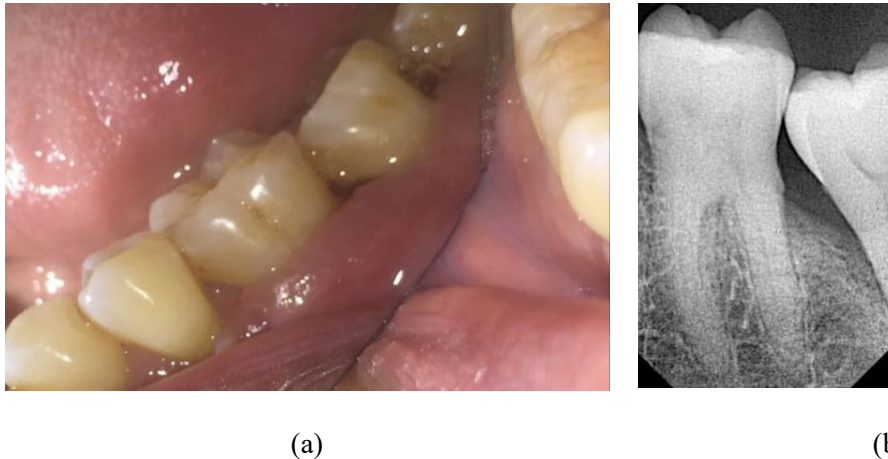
3 months post-operative a. pocket depth and clinical attachment level measurements b. periapical radiograph
